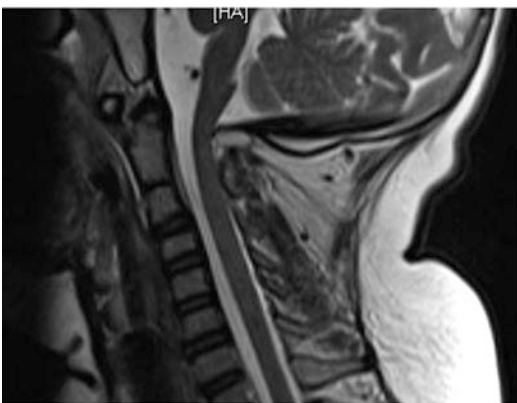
Immediately after reversal of anesthesia, with no neurological deficit, an MRI was performed showing posterior impingement on the cord by the edge of the foramen magnum (A previous MRI 3 years before had been normal)
